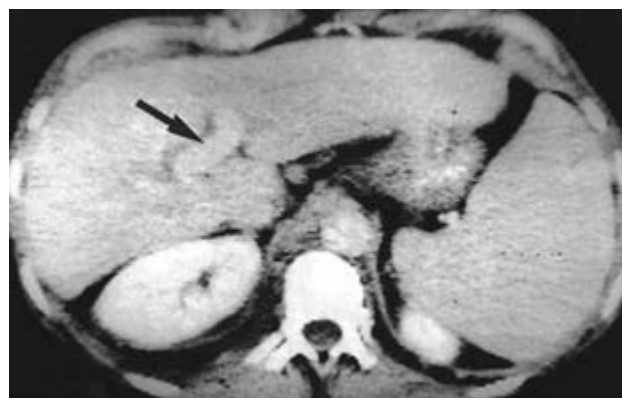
Contrast-enhanced abdominal CT scan from same patient as in fig. 28.5 shows a patent portal vein (arrow) and a large spleen.
